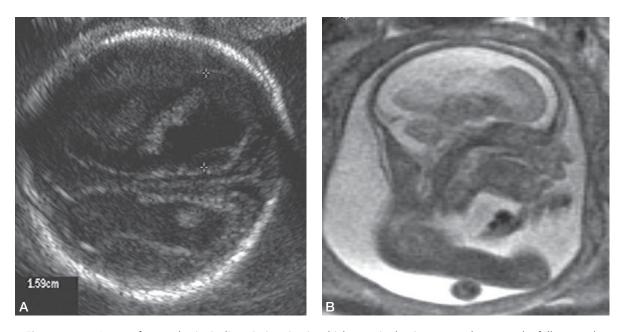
A case of monochorionic diamniotic twins, in which co-twin demise occurred at 13 weeks; follow-up ultrasound at 21 weeks demonstrating mild ventriculomegaly. (*With permission Weiss, et al. Multicystic encephalomalacia after first trimester intrauterine fetal demise in monochorionic twins.* Am J Obstet Gynecol. 2004;190:563-565.)
